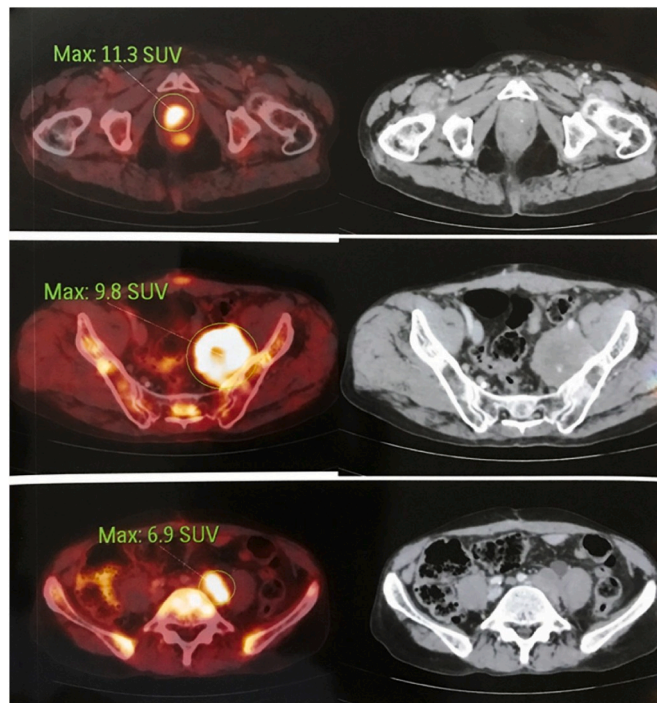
¹⁸F- FDG PET-CT scan showing metabolically active metastatic soft tissue density mass in left iliac region, metabolically active metastatic subcentimetric left paraaortic lymphnodes, metabolically active focal uptake in right lobe of prostate gland.
